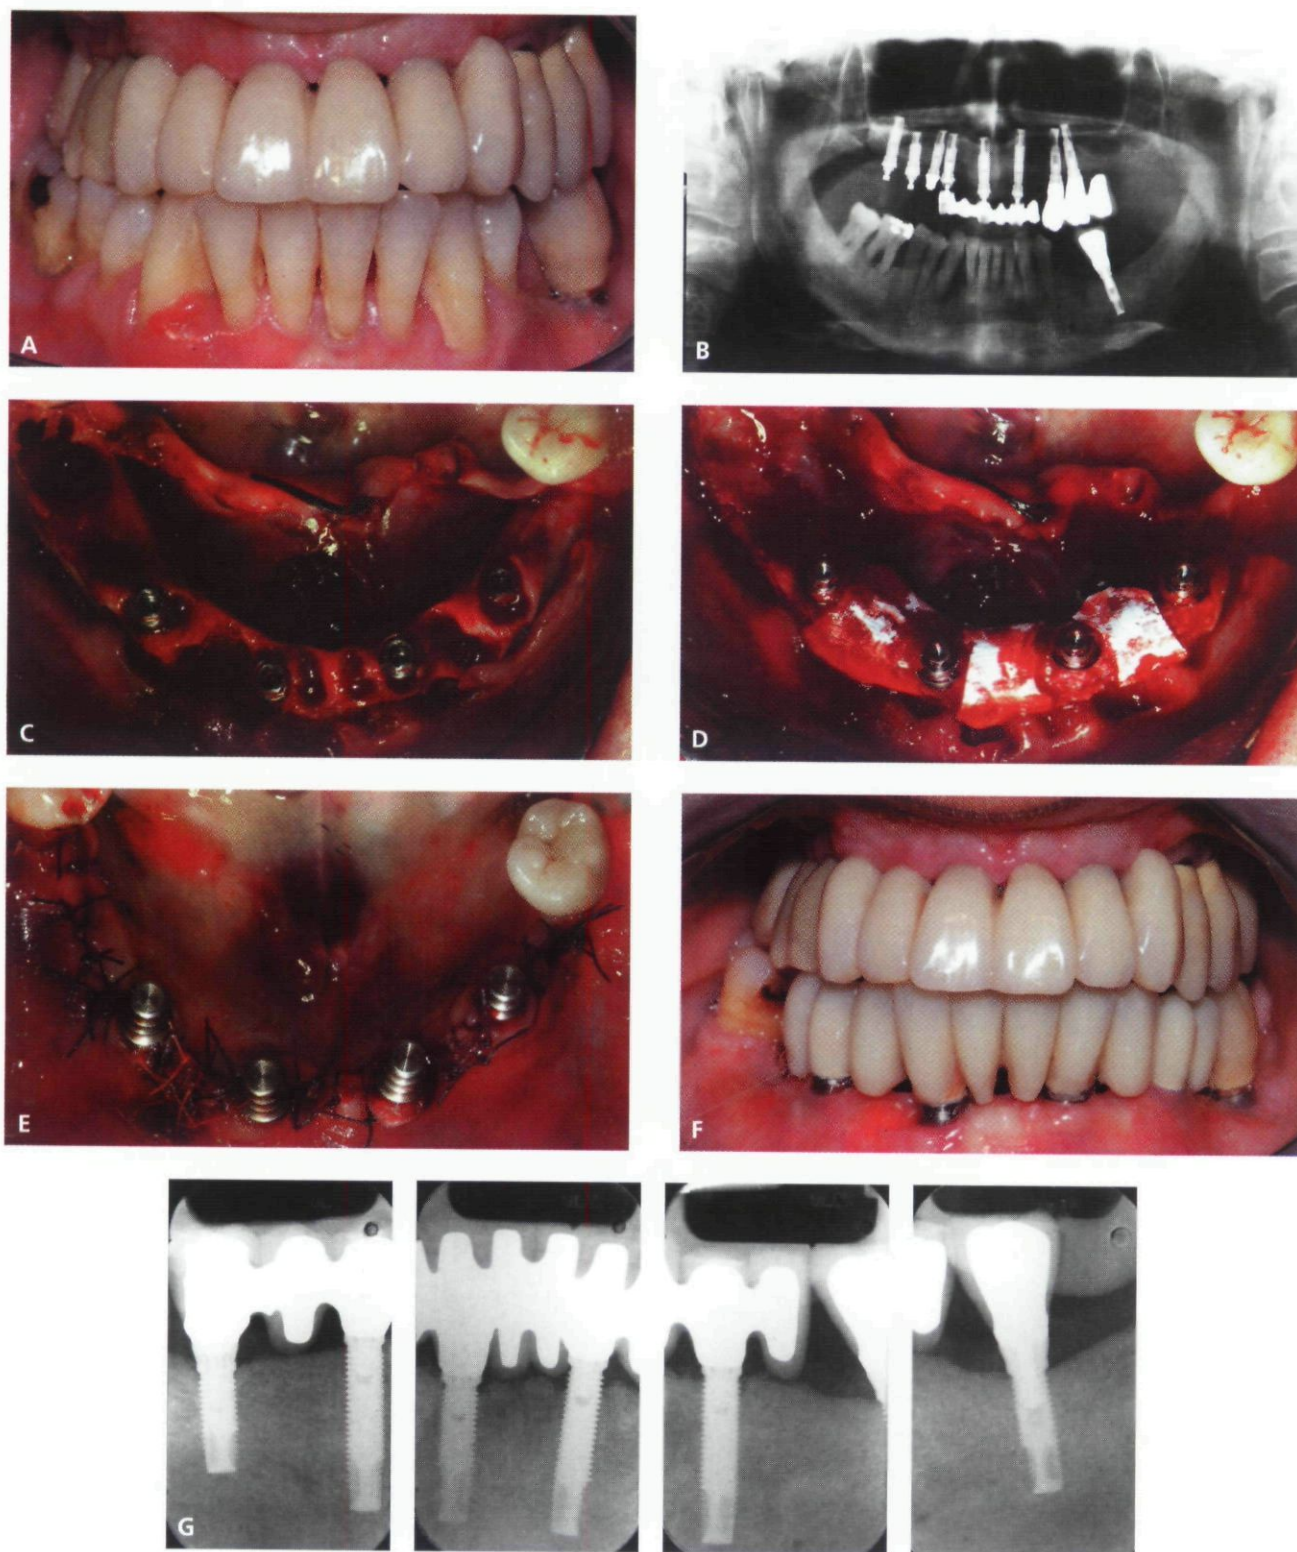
Clinical case of a female patient with advanced periodontal lesions in the mandible. *A*, Clinical pretreatment situation. *B*, Pretreatment radiograph. *C*, Extractions performed and implants placed. *D*, Abutments connected and bone grafting performed. *E*, Suture performed. *F*, Clinical image of the soft tissue healing 6 weeks postsurgery. *G*, Intraoral radiographs taken 23 months postoperatively showing good bone healing around the four implants placed in the interforaminal region. The radiographs also show two implants placed in a two-stage procedure in the molar area at different time points (one prior to and one after insertion of the four interforaminal implants).
